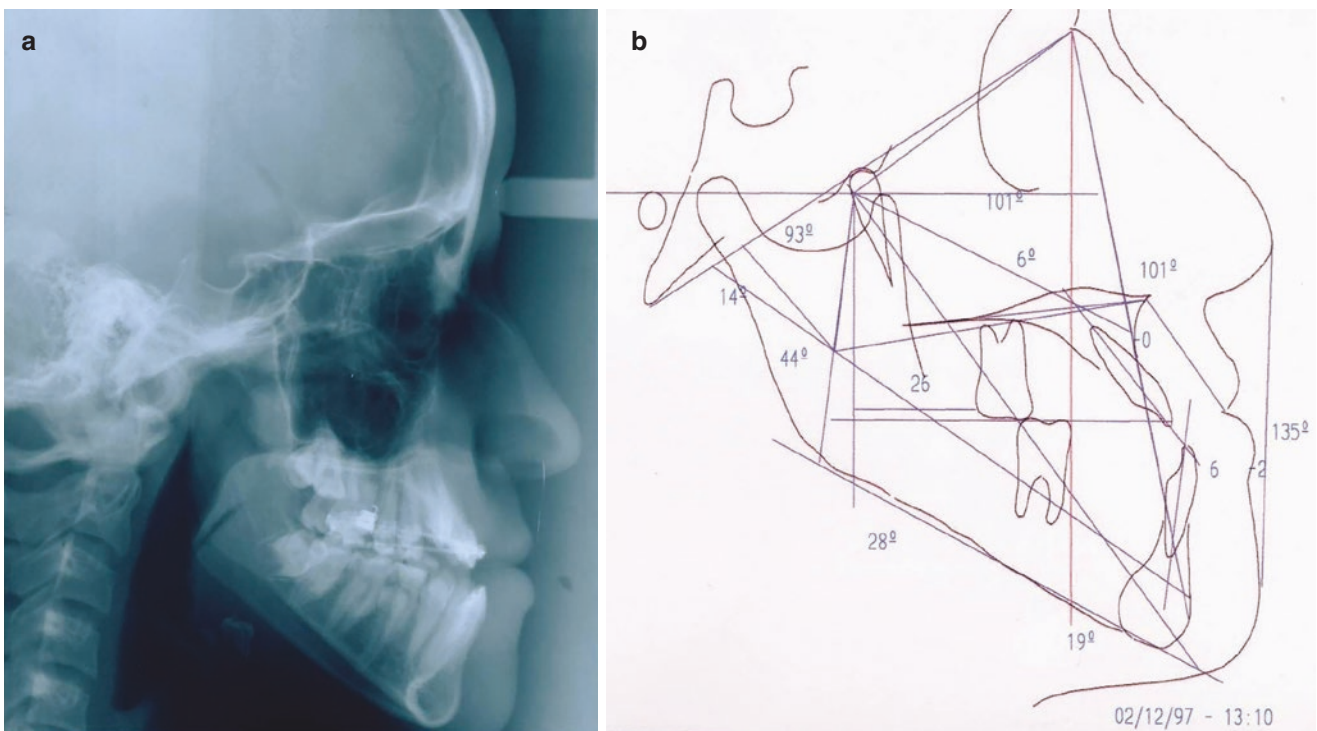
(a, b) Lateral radiographs and Ricketts analysis 5 years later. The results clearly showed the adverse direction of growth
